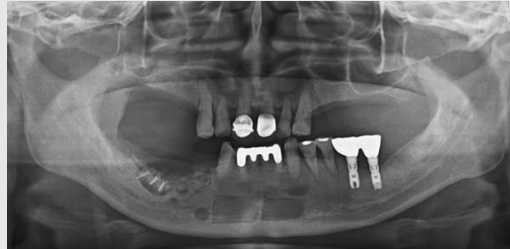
Radiographic evaluation after ridge augmentation by block bone graft and GBR simultaneously with removal of expander.
